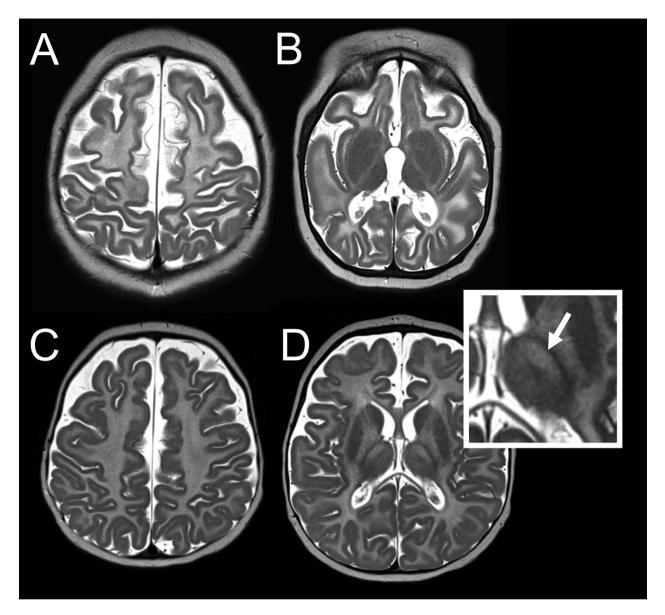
Additional findings beyond hypomyelination in *RARS1* variants. (A and B) T2-weighted axial images of patient 1 in the neonatal period, with simplified gyral pattern and thick posterior cortex. (C and D) Patient 15, at age 6 months, shows hyperintense T2-signal of the ventrolateral thalamus (arrow).
